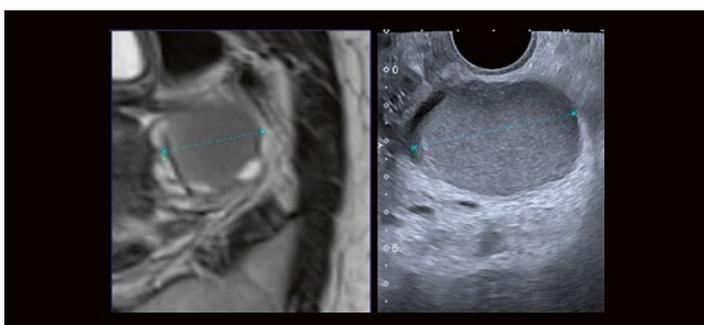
MRI and ultrasound parasagittal planes: endometrioma increased between MRI and Fusion.
